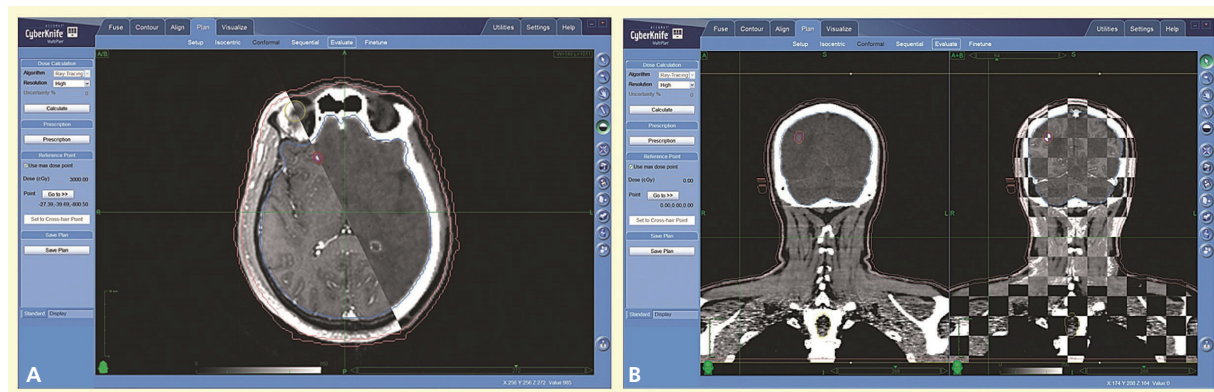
Fusion CT/MRI in axial images (A) and coronal (B) in patients with brain metastases.
